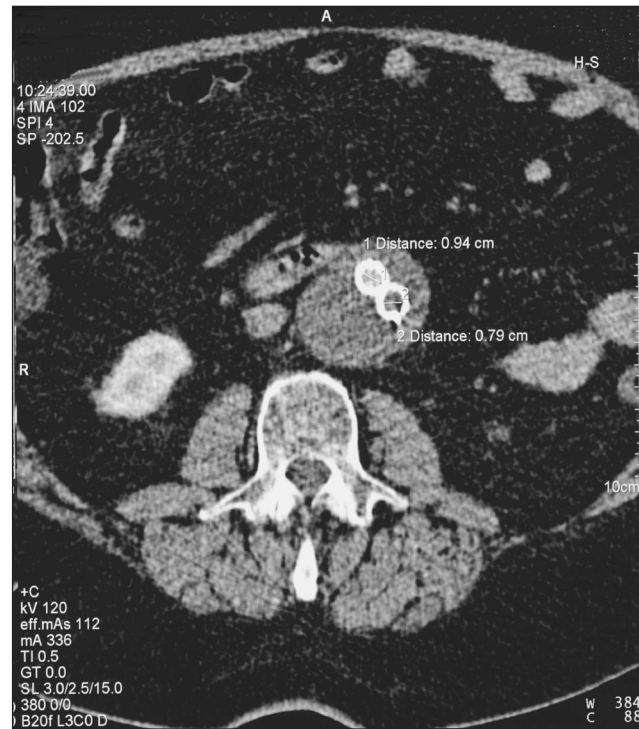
Computed tomography angiography at six months after new endovascular procedure showing aneurysm sac shrinkage
